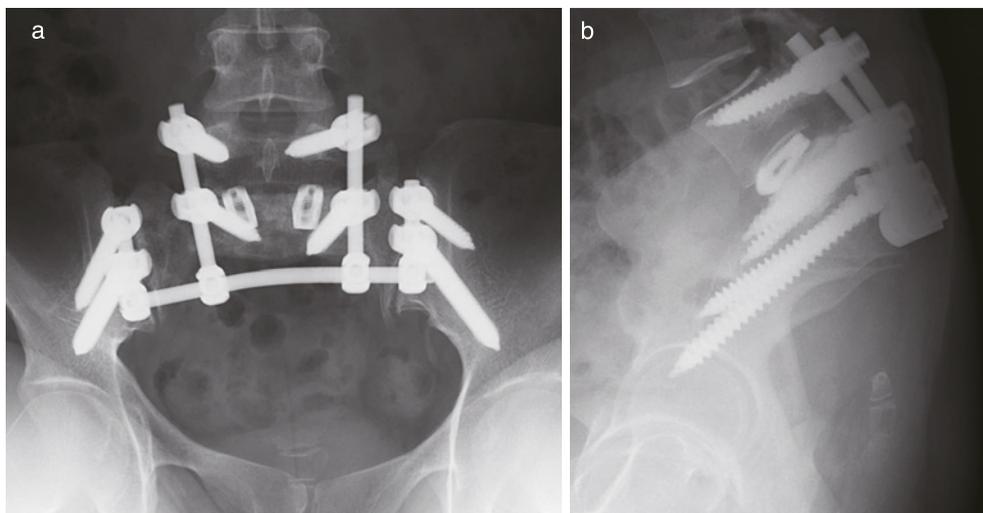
Anterior-posterior X-ray (a) and lateral X-ray (b) after surgery.
